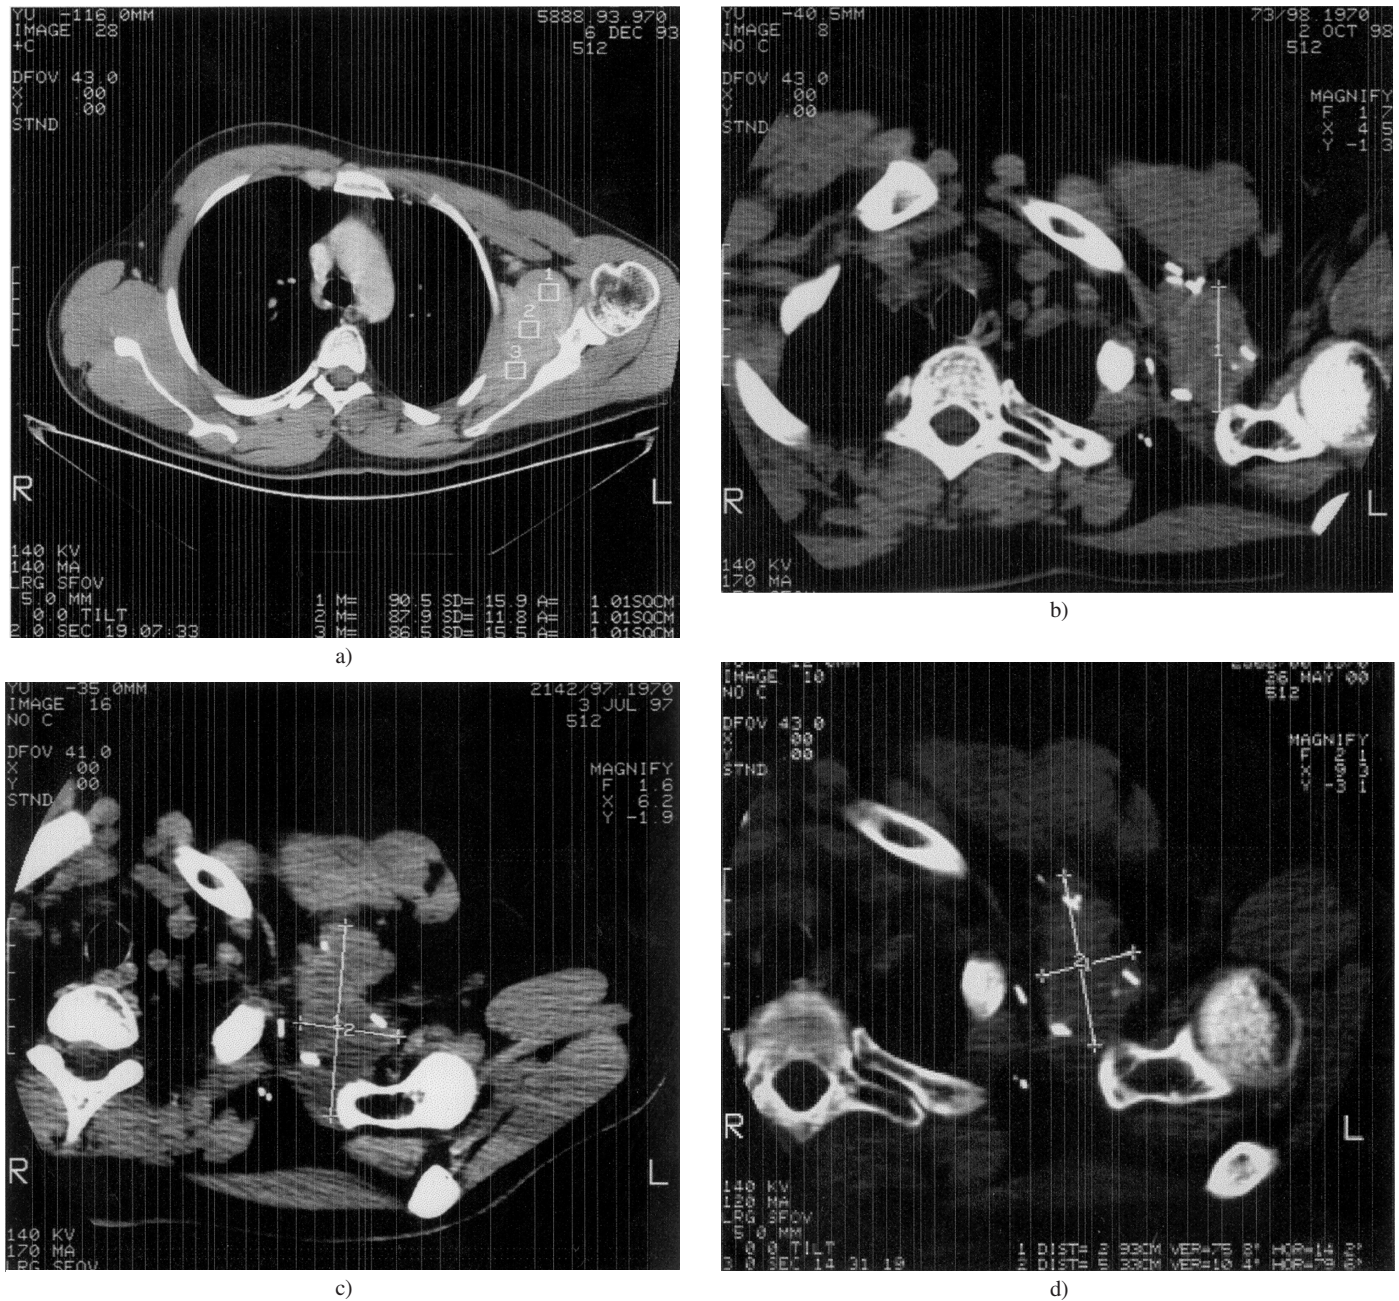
CT scans of supraclavicular fossa. 1a (upper left): primary lesion; 1b (upper right): local relapse after surgery and radiotherapy; 1c (lower left): tumour reduction after chemotherapy; 1d (lower right): no relapse at follow-up
